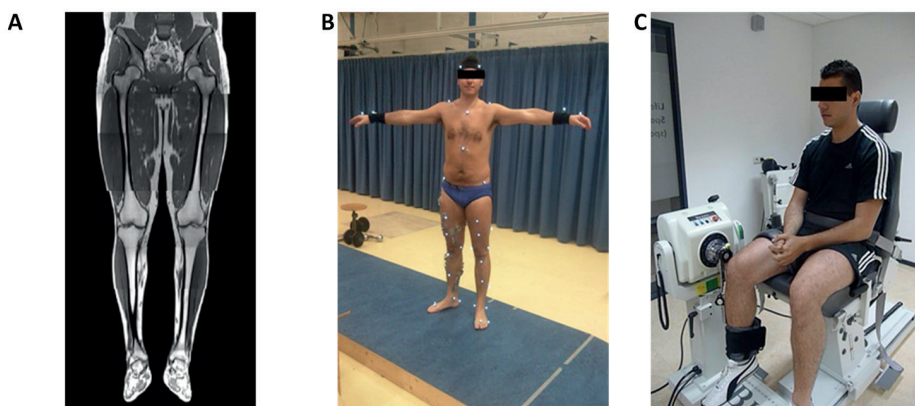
TLEMsafe healthy subjects' dataset. A. MRI scan of the lower extremities. B. Healthy subject wearing reflective markers and wireless EMG sensors during a recording session of 3D motion analysis and force plate data. C. Measurement of isometric and isokinetic torques during maximal voluntary contraction using a Biodex Dynamometer (Biodex Medical Systems).
